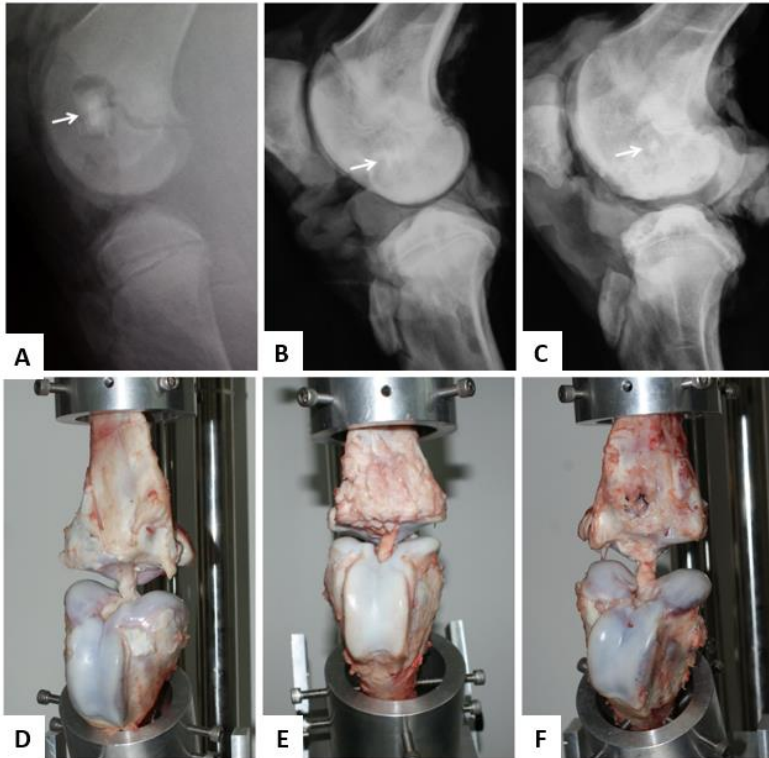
X-ray images of the knee with reconstructed ACL, at different postoperative time points.
